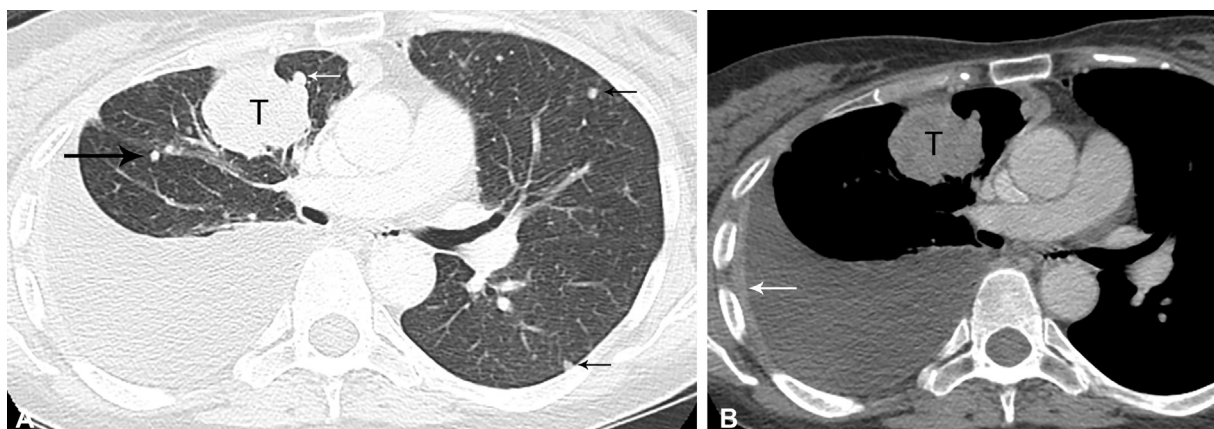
A 60-year-old woman with M1a disease. (A) Contrast-enhanced CT shows 4-cm primary tumor (T) in the right upper lobe. Separate nodule in the same lobe (white arrow) as the primary tumor is T3 disease. Separate nodule (long black arrow) in the right lower lobe, different lobe, same lung as the primary tumor is T4 disease. Separate nodules in the contralateral lung (small black arrows) constitute M1a disease, intrathoracic metastatic disease. (B) Contrast-enhanced CT shows the primary tumor in the right upper lobe and a moderate right pleural effusion with right pleural thickening (white arrow). Thoracentesis showed malignant pleural effusion, also M1a disease. Staging is determined by the highest descriptor and thus the final stage is stage IVA. CT, computed tomography.
